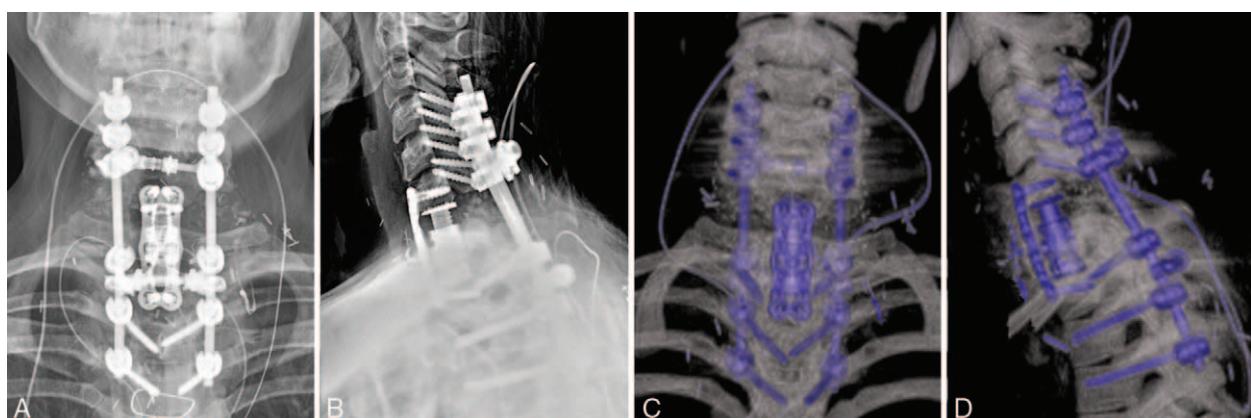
Postoperative imaging showing the operative construct after anterior C7-T1 intraleisional corpectomy and titanium cage reconstruction, followed by C7-T1 partial laminectomy and posterior element resection with anterior C6-T2 and posterior C4-T4 stabilization. Anteroposterior (A) and lateral (B) radiographs and volume-rendered frontal (C) and lateral (D) projections from CT.
